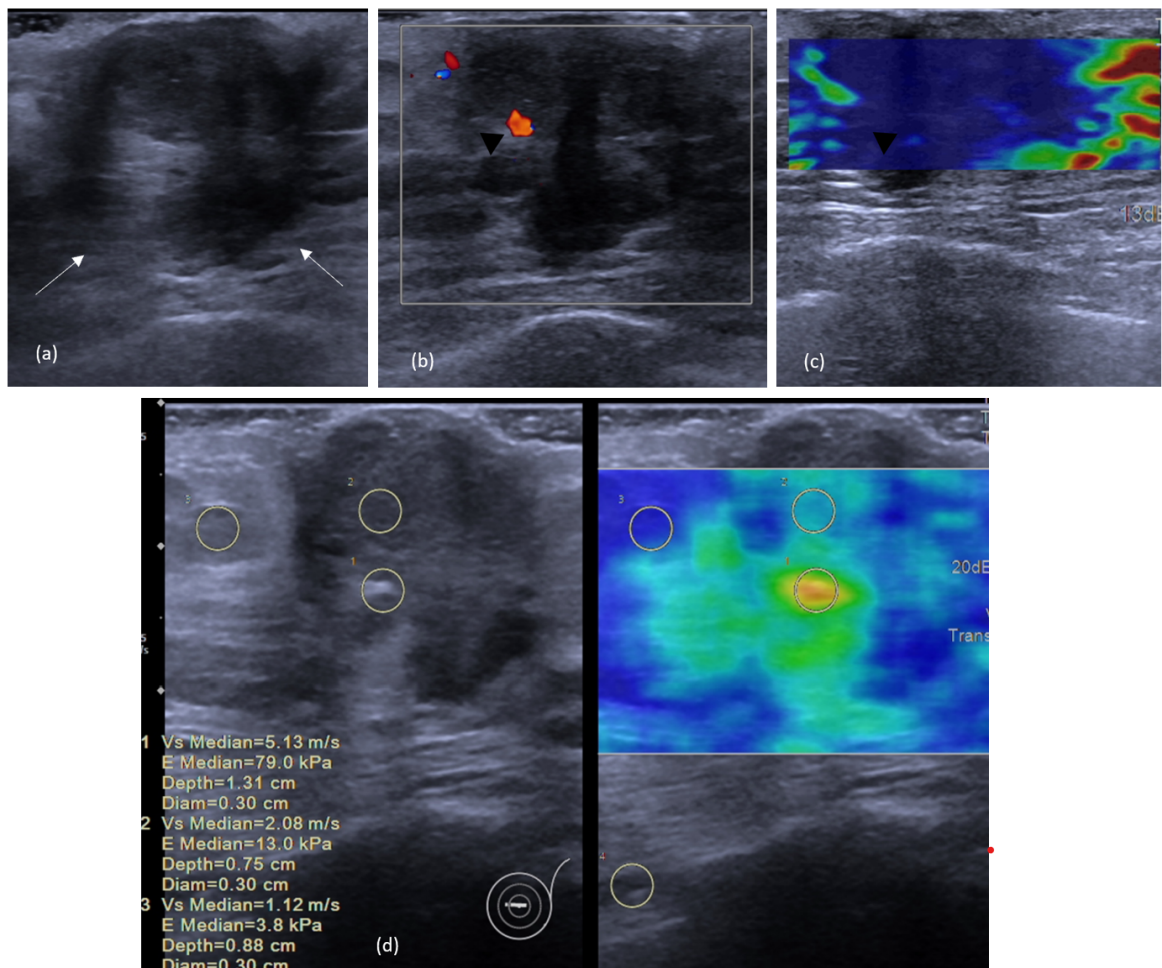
Ultrasonography images of left retro-areolar lesion. (a) White arrows show the irregular, non-circumscribed, non-parallel and heterogeneously hypoechoic appearance of the lesion. (b) Black arrow head indicates presence of vascularity within the lesion. (c) Tsukuba score 5 of the lesion based on elastography study. (d) Shear wave elastography study shows the stiffness of the lesion
